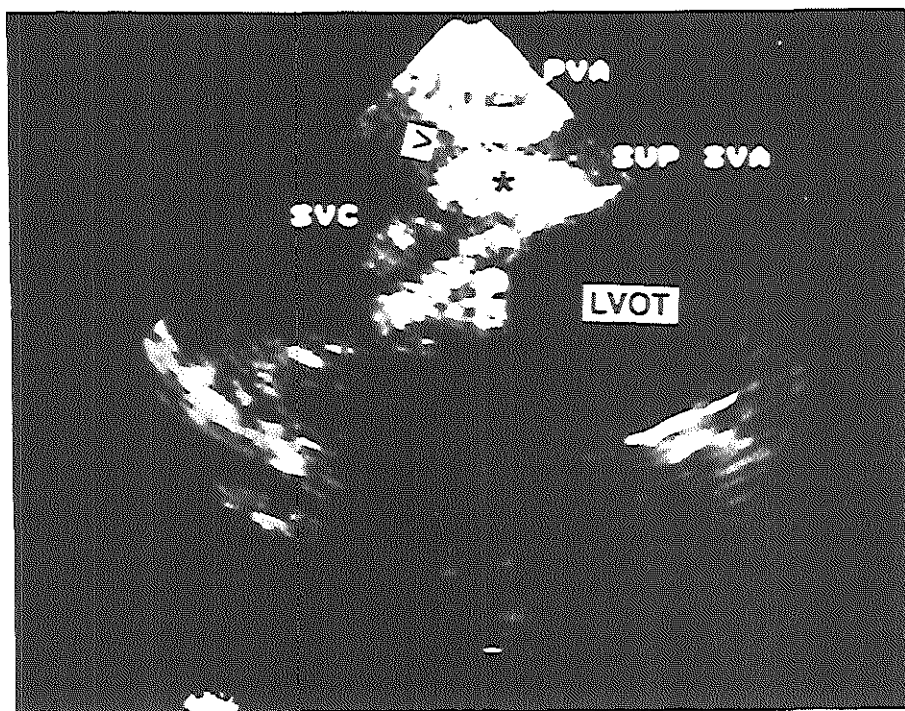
Case 12. Transoesophageal cross-sectional imaging of a severe obstruction in the superior limb of the systemic venous pathway after a Mustard procedure. The obstructive lesion (*) is heavily calcified, leaving only a pinhole opening of 1 mm (>). PVA = pulmonary venous atrium; SUP SVA = superior limb systemic venous atrium; SVC = superior vena cava; other abbreviation as in Figure 2.
